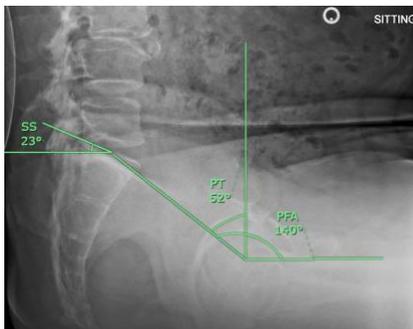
Spinopelvic parameters measured on sitting radiograph: sacral slope (SS), pelvic tilt (PT), proximal femoral angle (PFA).
